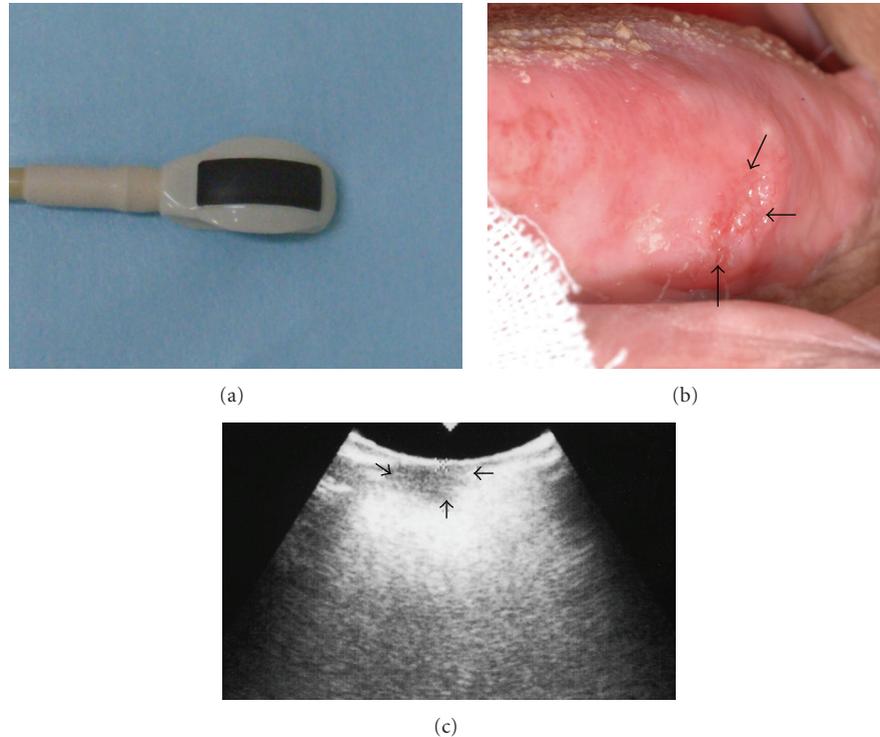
(a) View of the probe for intra-oral ultrasound examination. (b) View of the tumor in a 65-year-old man with carcinoma (arrows) on the left side of the tongue. (c) An ultrasound image showing the precise thickness of the tumor on the left side of the tongue (arrows) using intra-oral ultrasonography.
